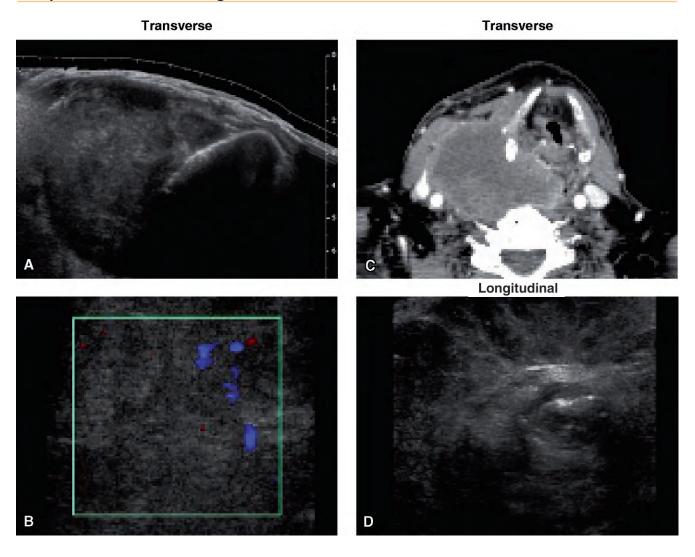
Ultrasound of anaplastic carcinoma in the right lobe. A, Transverse. B, Color Doppler, Transverse. C, CT Transverse. D, Longitudinal.
